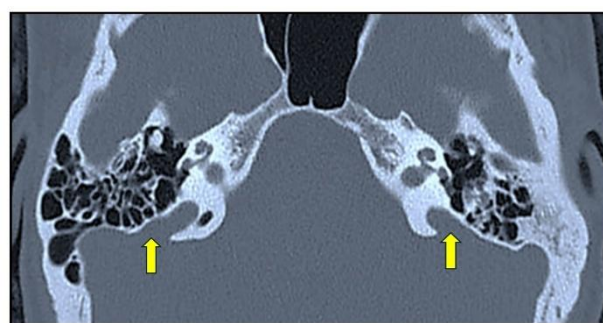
HRCT scan (coronal view) of temporal bone showing bilateral EVA.
